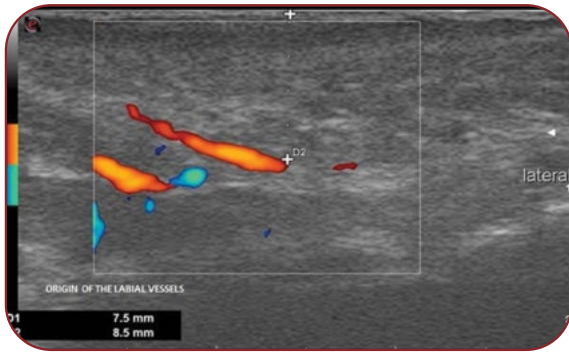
Doppler ultrasonography of the origins of the labial arteries
